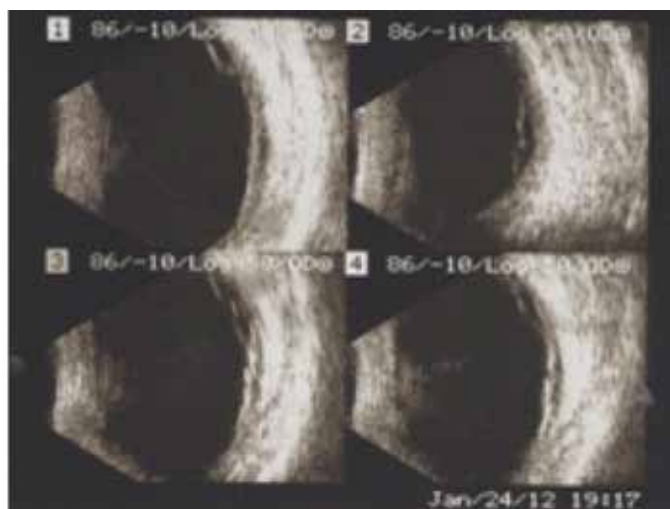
Ultrasonography B-scan of right eye showing exudative retinal detachment.
